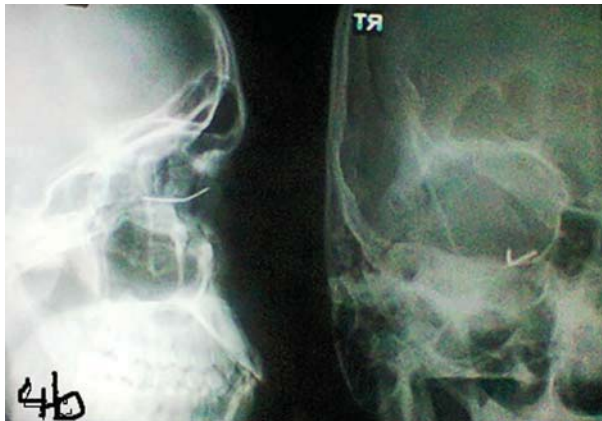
X-ray.OFB (metallic pin) near globe.
